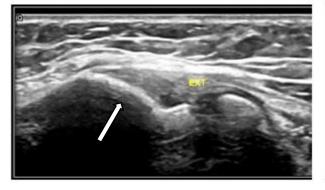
51 years old female complaining of Right lateral elbow pain extending to the dorsum of the forearm for about 6 months .Grey scale ultrasound scan revealed thickening of the CET, associated with area of focal hypo echogenicity "arrow" (Fig. A) and cortical irregularities at the lateral humeral epicondyle denoting lateral epicondylitis with osseus changes "arrow head" (Fig. B). MRI images revealed mild thickening of the CET, associated with focal area of intra tendinous hyperintensity seen within common extensor tendon near itshumeral attachment at Coronal STIR "arrow" (Fig. C), and axial T2 images "arrow head" (Fig. D), no tendon tear or retraction.
